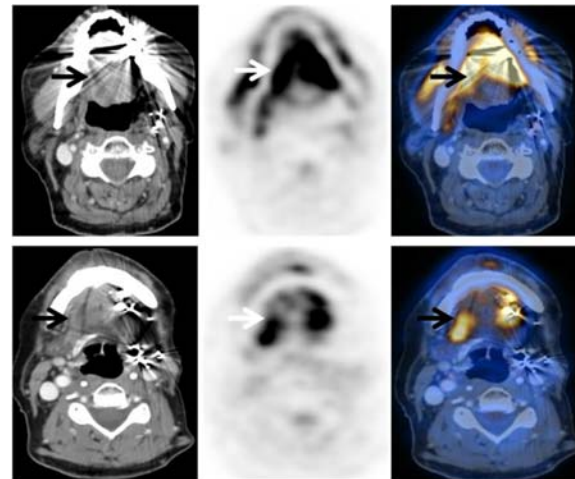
A 59-year-old male with a history of left tongue cancer status post surgery, combination therapy with chemo- and radiation therapy 3 years earlier. Two slices of axial images of a PET/CT study demonstrate increased FDG uptake within the tongue, particularly in its extrinsic muscles (arrow) without any evidence of a discrete mass seen on the corresponding contrast enhanced CT scan, most consistent with physiologic uptake. Of note, the patient was later reported to be chewing gum during the incubation period of FDG uptake
